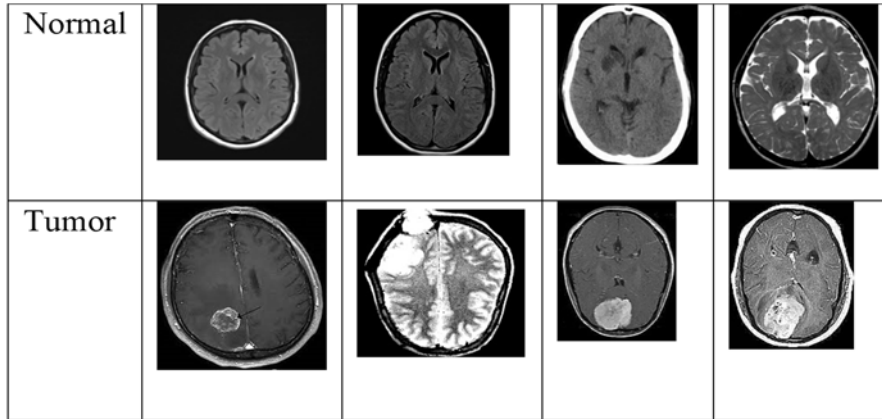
Sample MR images of the BT-large-2c dataset.
